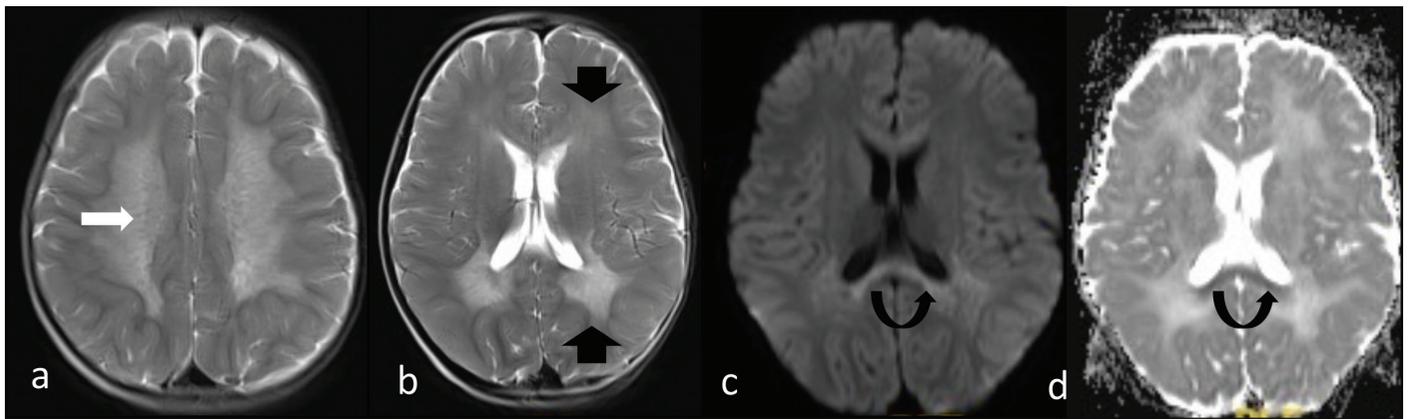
Axial MR images of patient 5; a-b: The typical pattern of distribution of white matter hyperintensity in T2 weighted images (black arrows), tigroid pattern formed from T2 hypointense stripes and dots in the background of diffuse hyperintensity (white arrow); c-d: restricted diffusion within the splenium of the corpus callosum (black arrows)
